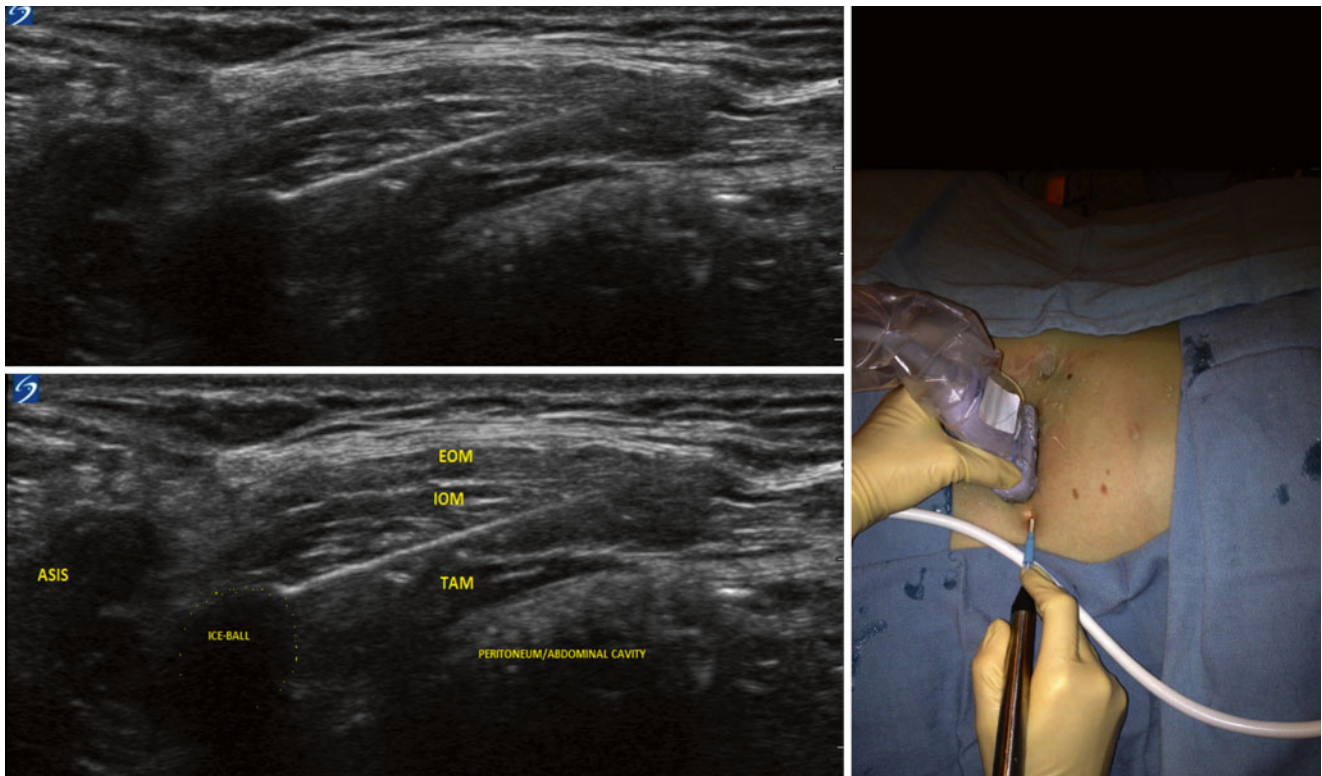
Cryoneuroablation of the ilioinguinal nerve under ultrasound guidance. *ASIS* anterior superior iliac spine, *EOM* external oblique muscle, *IOM* internal oblique muscle, *TAM* transversus abdominis muscle (Image courtesy of Agnes Stogicza, MD)
